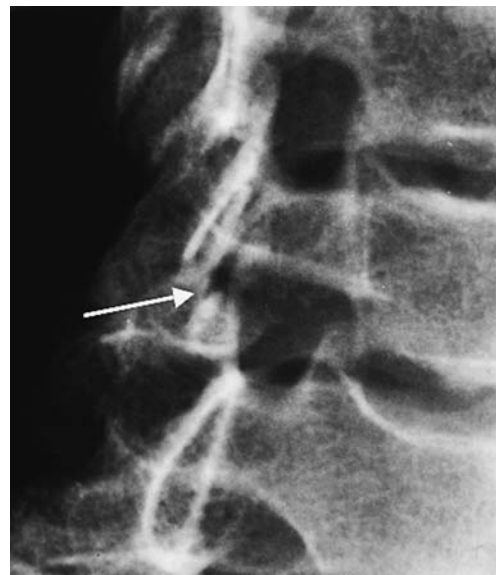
Laminar fracture. Oblique view radiograph. The fracture line (*arrow*) is confined to the lamina
